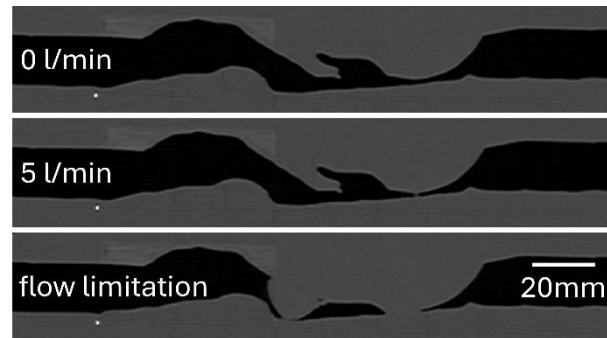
Sagittal (longitudinal) view of the airway CT images. Top: no flow (baseline); middle: moderate inspiratory flow (~ 5 l/min); bottom: flow limitation with near-complete collapse (flow ≈ 0 l/min) at two anatomical landmarks: the soft palate and the base of the tongue.
